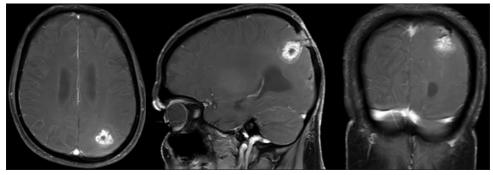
Follow-up contrast-enhanced magnetic resonance imaging at 6 months showing the lesion further shrinking in size with reduction of the edema
